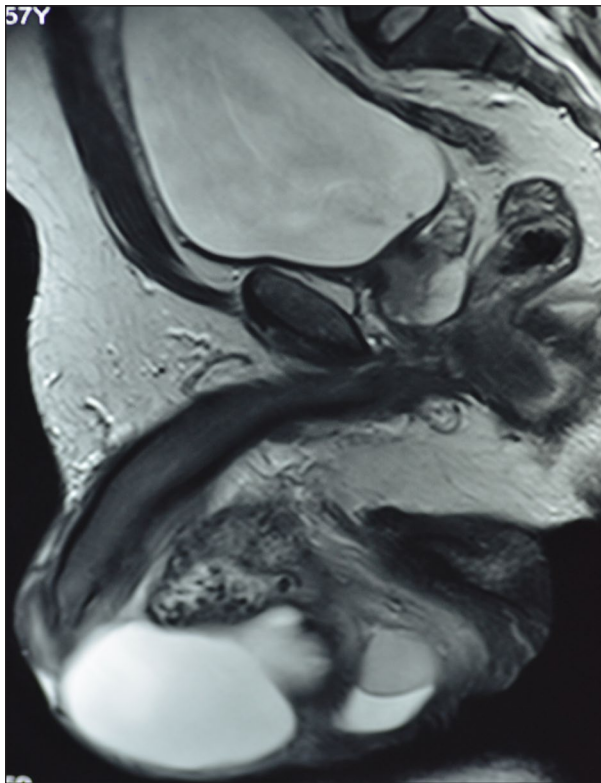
MRI showing mycetoma invading the right epididymis, ascending along the spermatic cord ending proximally at the level just below the tubercle of the right pubic bone with the involvement of the posterolateral aspect of the right hemiscrotum and the scrotal septum.
